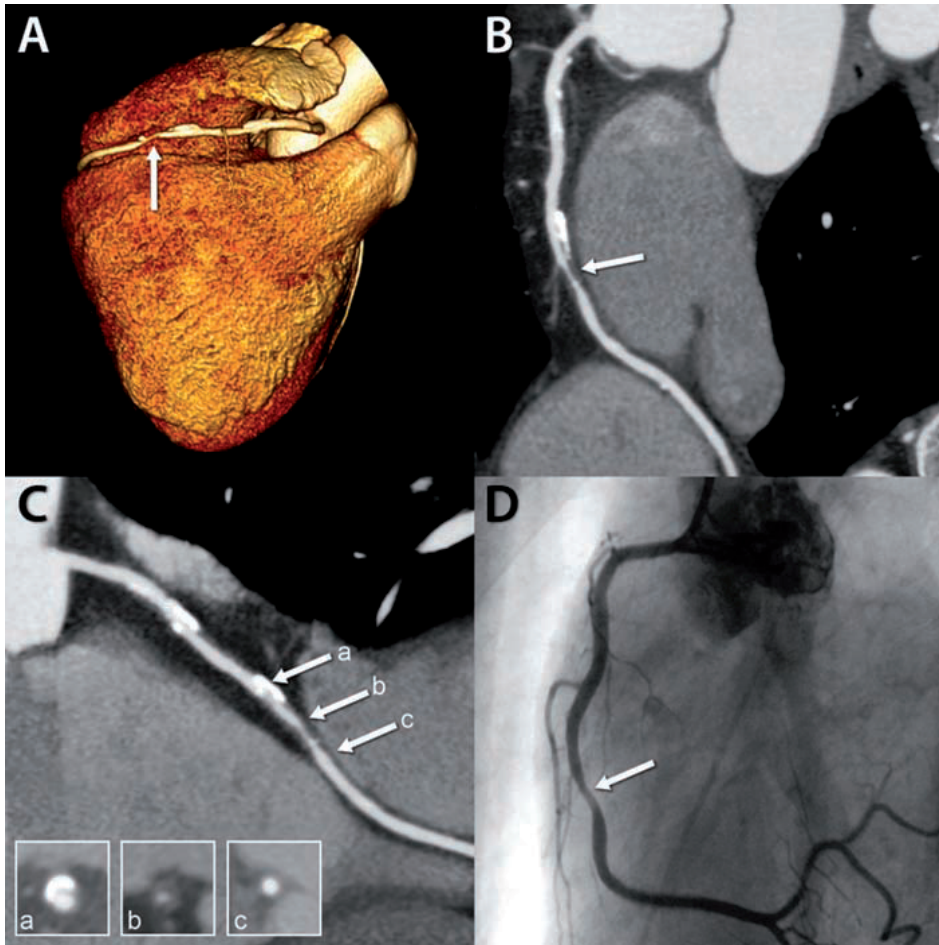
Example of non-invasive coronary angiography with CT in a patient presenting with suspected ACS.
